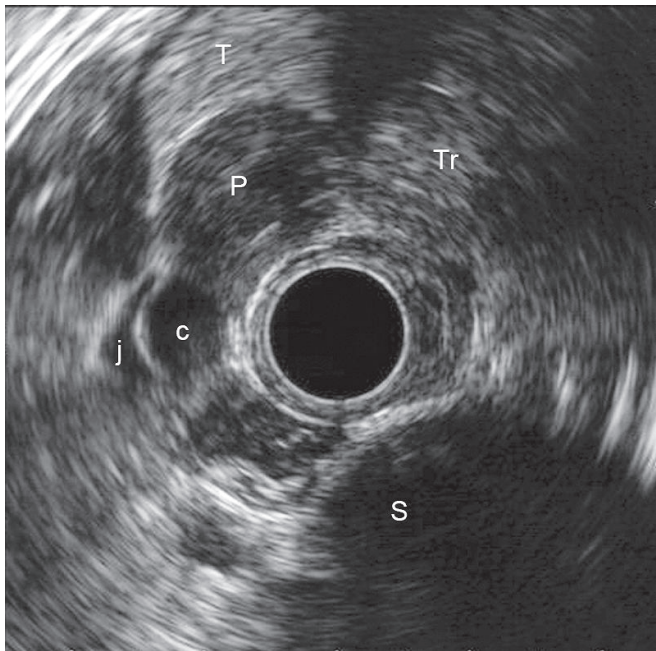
Radial EUS image from the upper esophagus. The parathyroid adenoma (P) is seen as a well-demarcated hypo-echoic lesion located within the right thyroid lobe (T). There is no invasion into the jugular vein (j) or internal carotid artery (c). Ultrasound views beyond the spine (S) and the trachea (Tr) are obscured due to calcification and air respectively.
